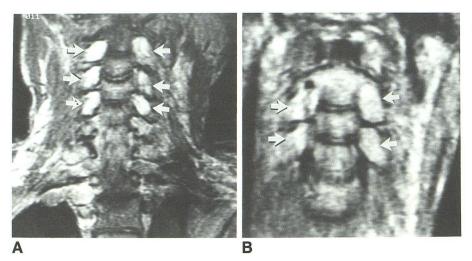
A and B, Coronal T2-weighted MR images of twin 1 (A) and twin 2 (B). Mirror-image bilateral neurofibromas (arrows) are present at multiple levels in cervical spine.
